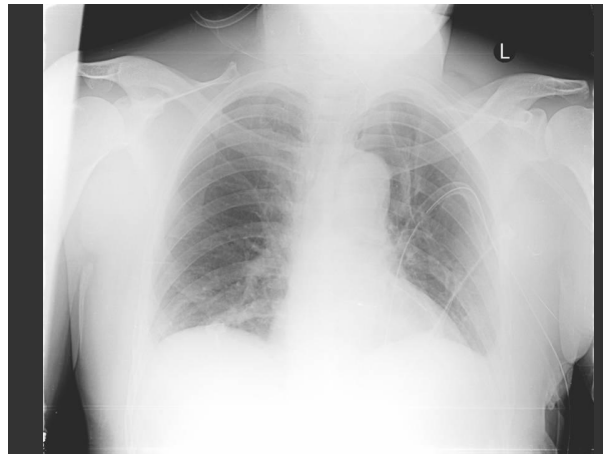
Follow-up Portable Chest Radiograph
